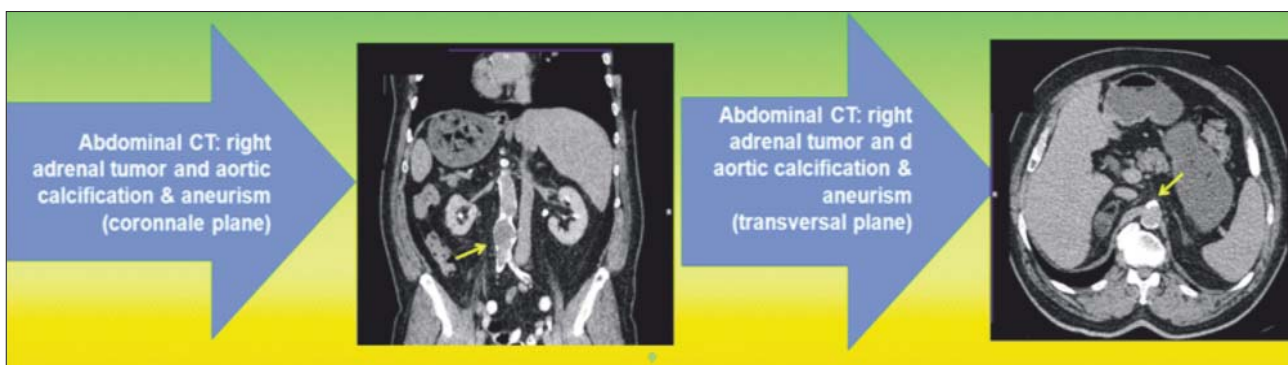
Contrast computed tomography showing the aortic anomalies on a patient with right adrenal tumour and high blood pressure (different sections and planes)
